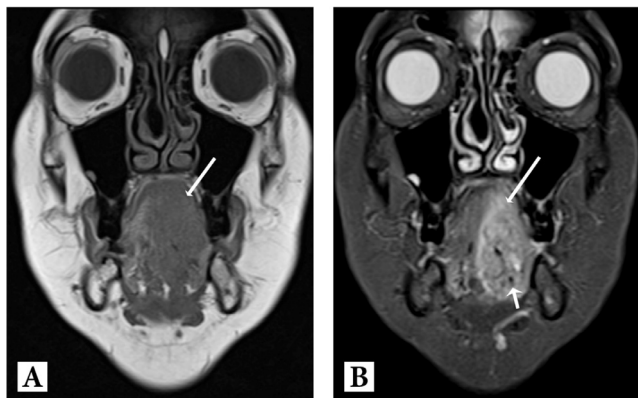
T1 (A) and T2 STIR (B) images show a large ill-defined lesion involving the entire tongue (large arrow). It is isointense to muscle on T1-weighted images and heterogenous on T2-weighted images. There are small hypointense areas seen within the lesion (small arrow). The lesion crosses the midline and involved the left genioglossus muscle.
